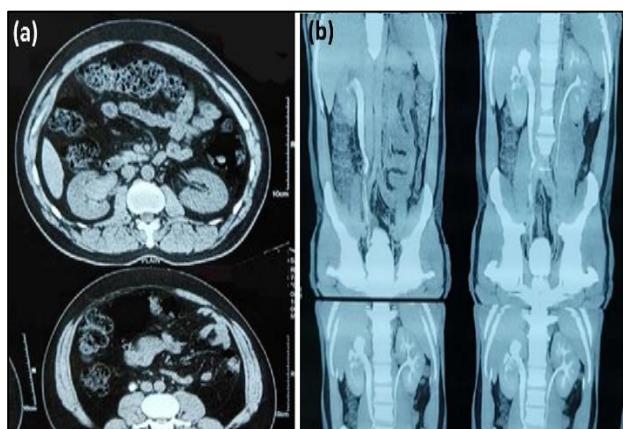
(a and b): CT urography image showing right upper ureteric calculus with proximal hydroureteronephrosis and blood in PCS.
